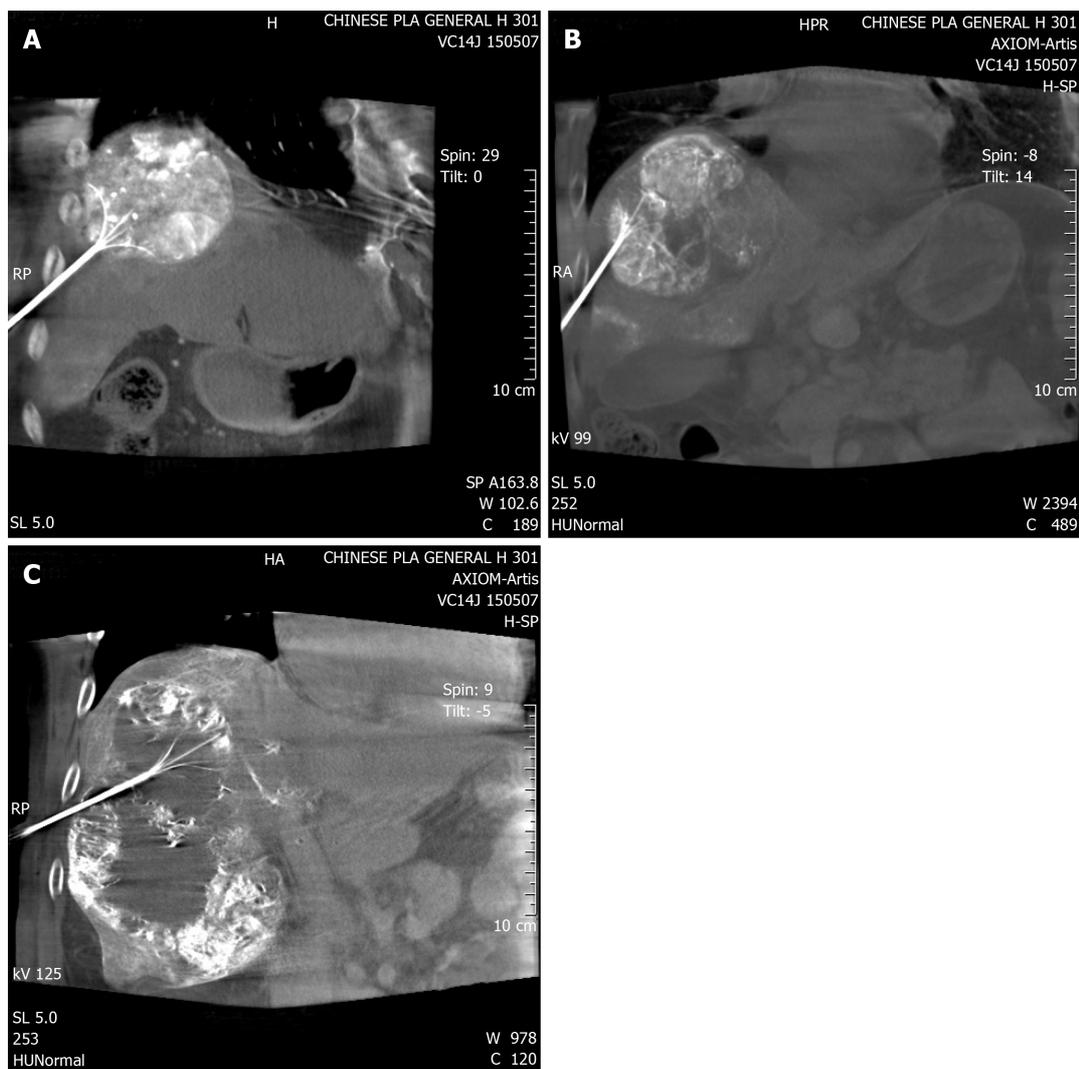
Cone-beam computed tomography image confirmed the position of the radiofrequency probe. A-C: Radiofrequency probe inserted at an angle to avoid lung damage.
